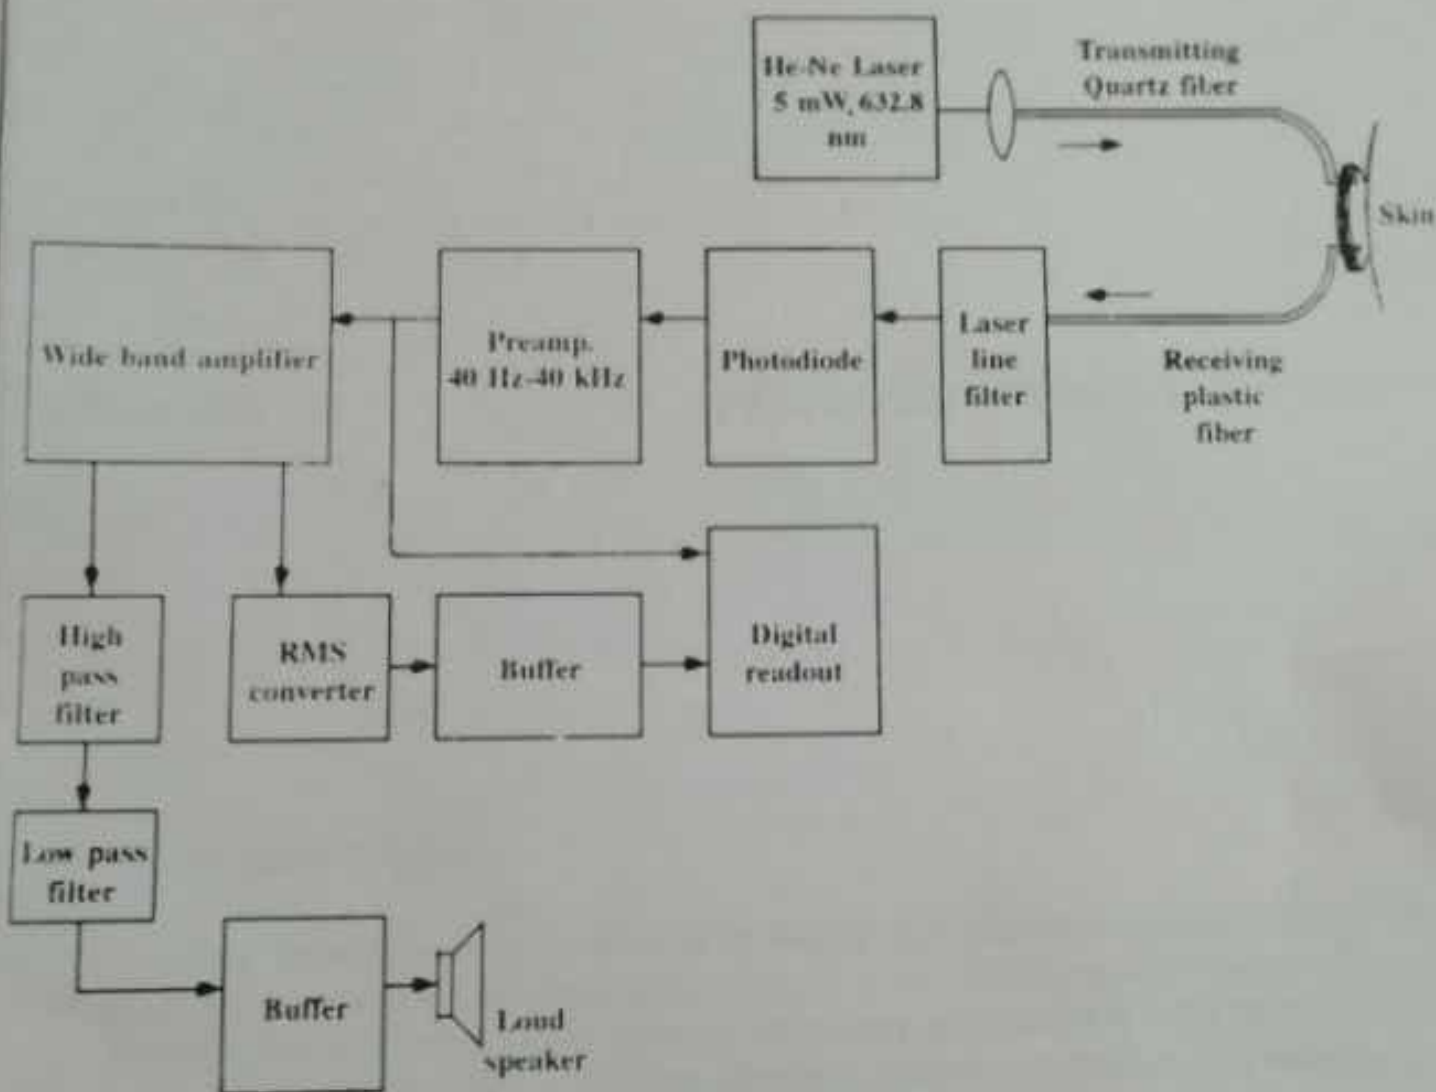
Laser doppler blood flowmeter
